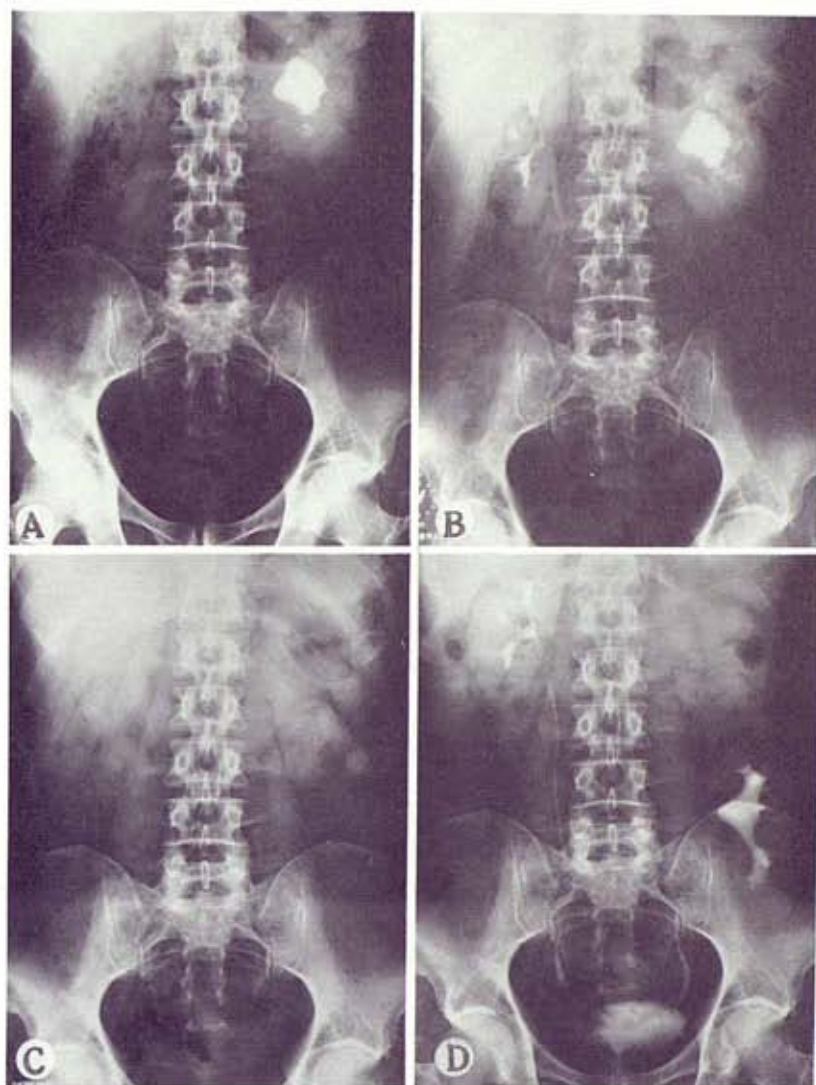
Case 2. A, x-ray reveals multiple and relapsing renal lithiases. B, IVP reveals functional delay and noticeable pyeloectasia of malrotated left kidney. C, postoperative x-ray shows complete removal of calculi. D, postoperative IVP reveals autotransplanted kidney in left lumboiliac position.
